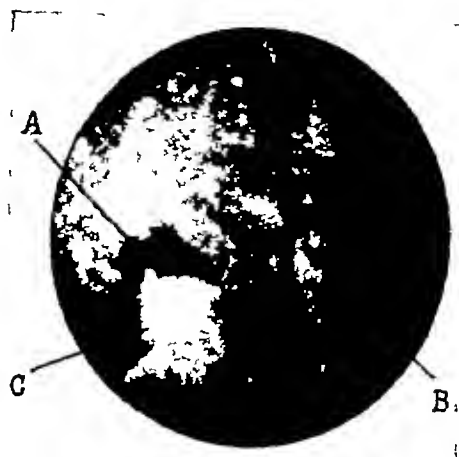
A photograph of the pyloric region of a patient whose roentgen examination showed abnormal spasticity in the lower part of the stomach and a filling defect in the prepyloric region suggesting the presence of a mass which was diagnosed as a probable carcinoma. A shows the pylorus in the background partially obstructed by a mass of redundant mucosa. C. At B we see a small ulcer on the border of the spastic fold.
